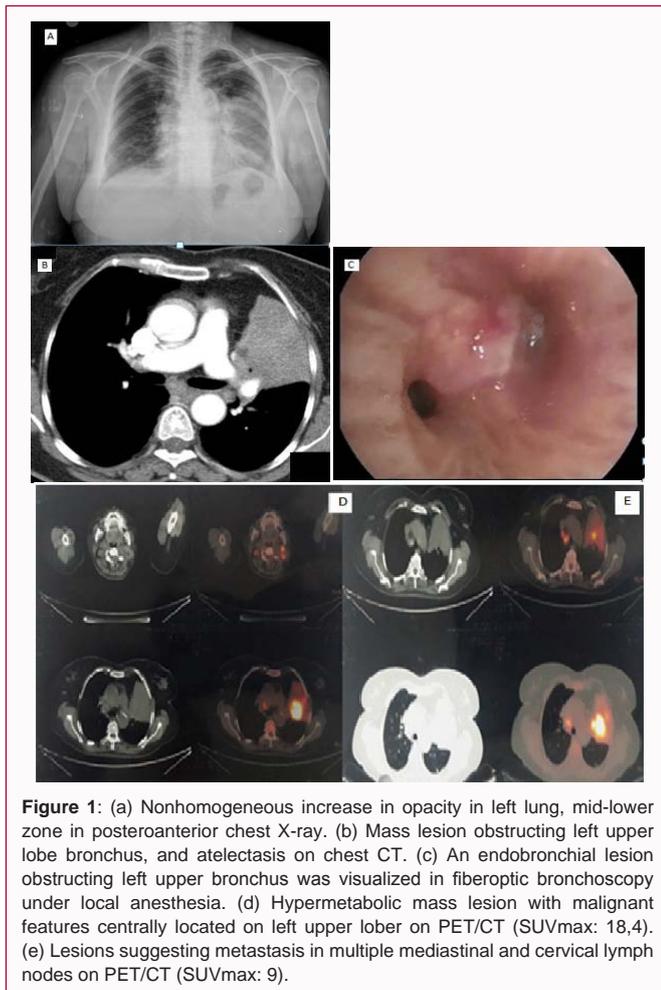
(a) Nonhomogeneous increase in opacity in left lung, mid-lower zone in posteroanterior chest X-ray. (b) Mass lesion obstructing left upper lobe bronchus, and atelectasis on chest CT. (c) An endobronchial lesion obstructing left upper bronchus was visualized in fiberoptic bronchoscopy under local anesthesia. (d) Hypermetabolic mass lesion with malignant features centrally located on left upper lobe on PET/CT (SUVmax: 18,4). (e) Lesions suggesting metastasis in multiple mediastinal and cervical lymph nodes on PET/CT (SUVmax: 9).
